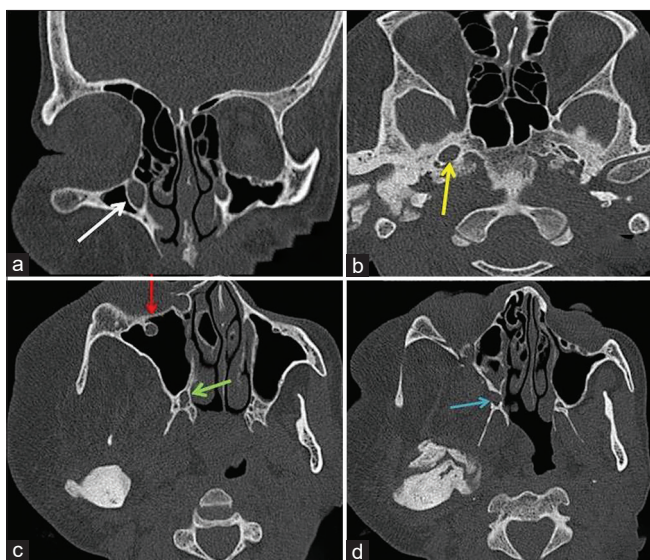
(a) Coronal computed tomography reformatted image (bone algorithm) shows enlarged right nasolacrimal duct (white arrow), (b) axial computed tomography image (bone algorithm) shows enlarged right foramen ovale (yellow arrow), (c) enlarged right inferior orbital foramen (red arrow) and greater palatine foramen (green arrow), and (d) enlarged right sphenopalatine foramen (blue arrow)
